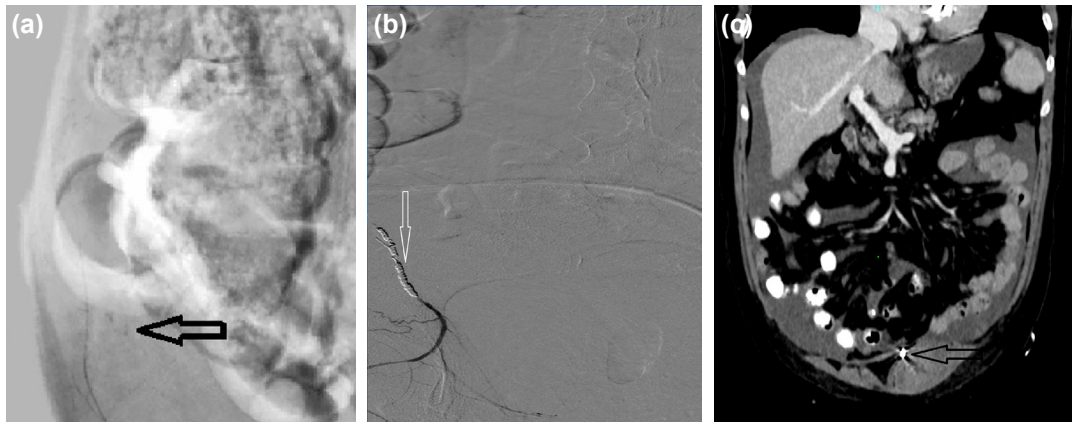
Digital subtraction angiography showing (a) extravasation from the right inferior epigastric artery (black arrow) and (b) embolisation with microcoil (white arrow). (c) Follow-up computed tomography showing the micro-coil and resolved left rectus sheath haematoma (black arrow).
